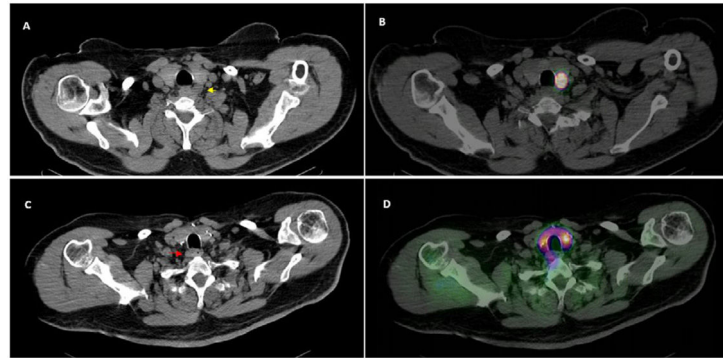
Patient with PHPT who underwent resection of a parathyroid adenoma (yellow arrow) located posterior to the caudal pole of the left thyroid lobe (A) by means of MIRP after ultrasound-guided administration of ^{99m}Tc -MAA. The transaxial fusion SPECT/CT image shows the correct intralesional location of the radiotracer (B). Hypercalcemia persisted one year later, and a new parathyroid lesion was observed (C) in a more caudal right paraesophageal ectopic location (red arrow) with significant uptake of ^{99m}Tc -MIBI as shown in the SPECT/CT fusion image, (D) which was satisfactorily removed in a second surgery, this time radioguided with MIBI.
